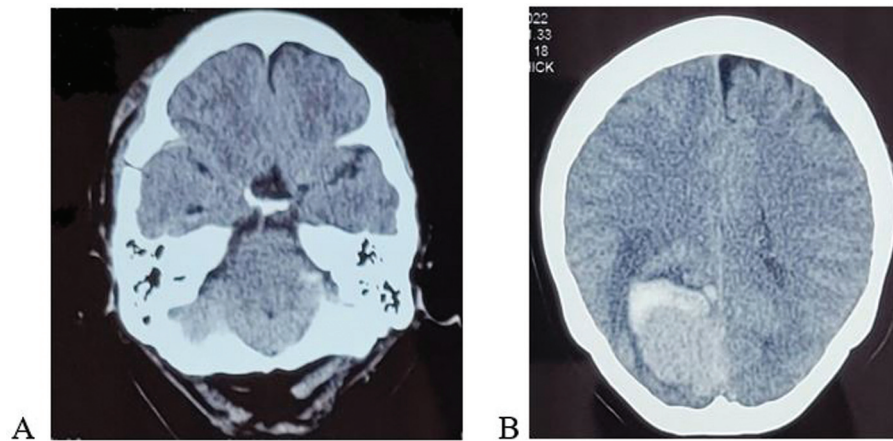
Postoperative brain computed tomography. Shows total resection of anterior skull base lesion (A) and spontaneous bleeding from right occipital lesion (B).
